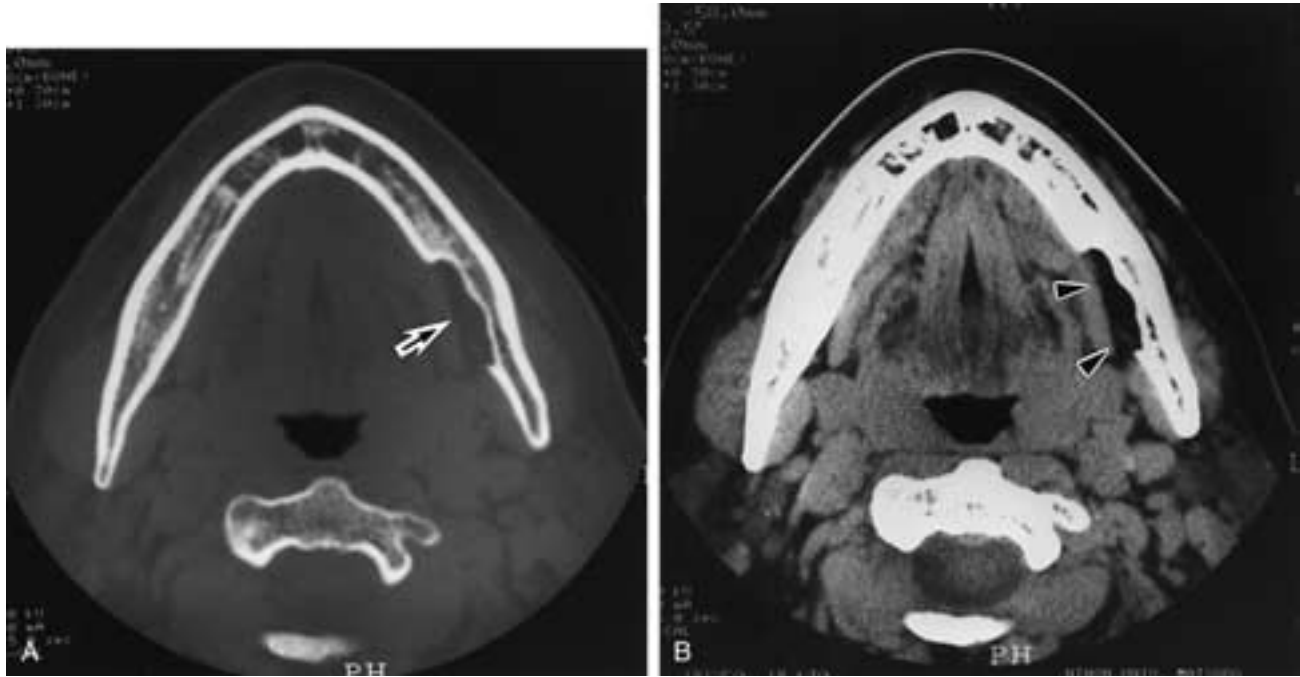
Static bone cavity (Stafne cyst). A, Axial CT (bone tissue window setting) shows a defect (arrow) with adjacent thinning of the lingual cortex. Note, however, that the cortex is complete along the lateral aspect of the abnormality. B, Axial CT (soft-tissue window setting) shows the static bone cavity containing adjacent fat (arrowheads).
